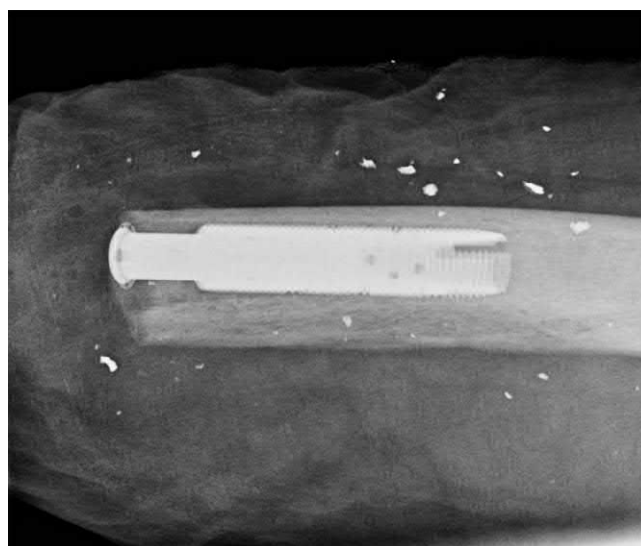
Lateral radiograph following stage one of the osseointegration procedure using the osseointegrated prosthesis for the rehabilitation of amputees device. Only the fixture is placed and the incision is closed. With time, bony ingrowth occurs at the threaded titanium surface of the implant.
